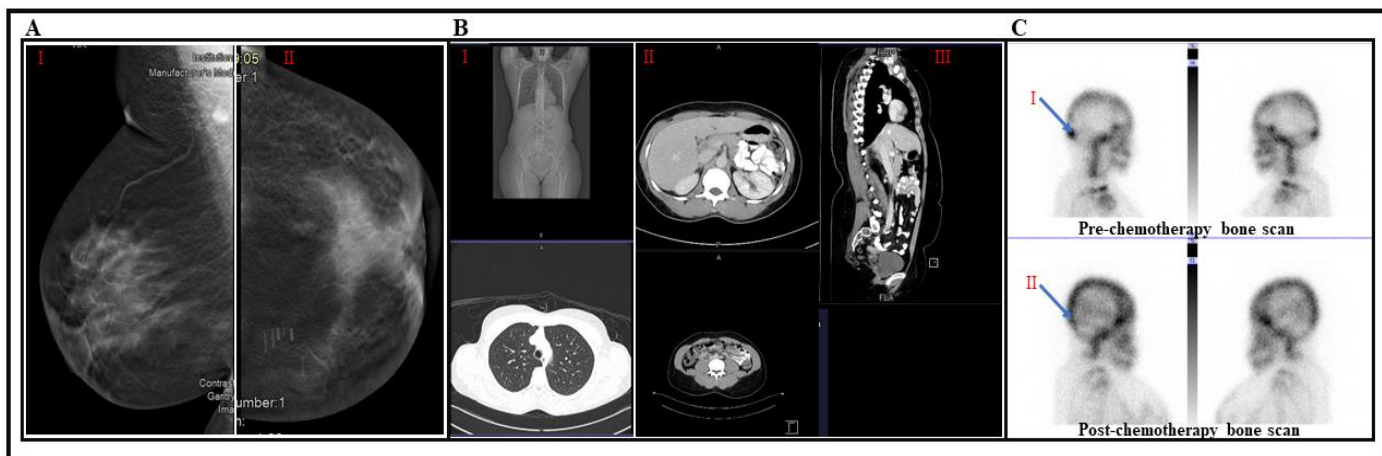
A) Mammography (MMG) shows BIRAD 2 (I) in the right breast and BIRAD 6 (II) in the left breast. B) CT scans of the chest, abdomen, and pelvis indicate no pulmonary or hepatic metastasis. C) A bone scan reveals scintigraphic evidence of osteoblastic skeletal metastases in the occipital bone (B.I). Complete resolution of the oligometastasis (B.II).
